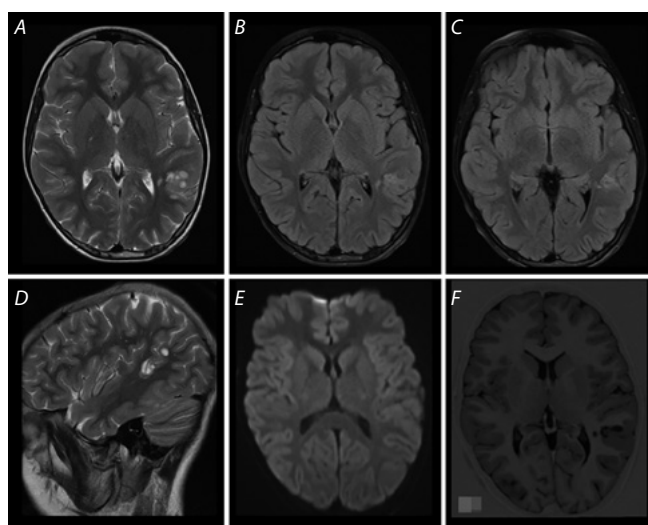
Brain MRI of patient G. at his first examination.
